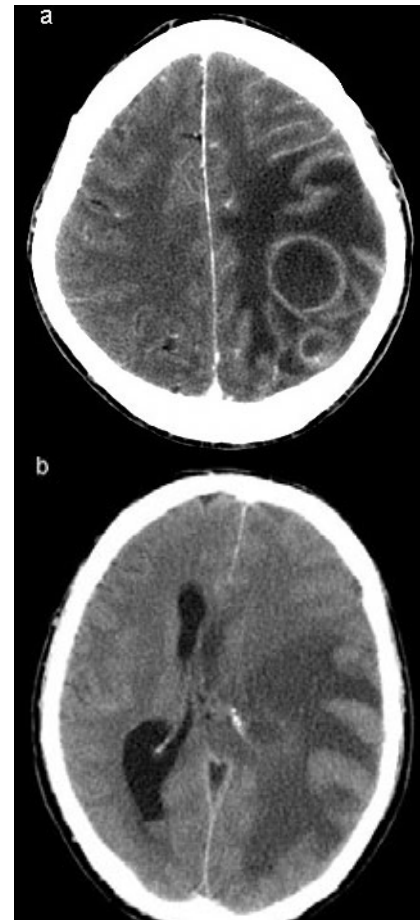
a – CT head demonstrating two ring enhancing intraparenchymal brain lesions; b – lesions were associated with surrounding edema and midline shift
